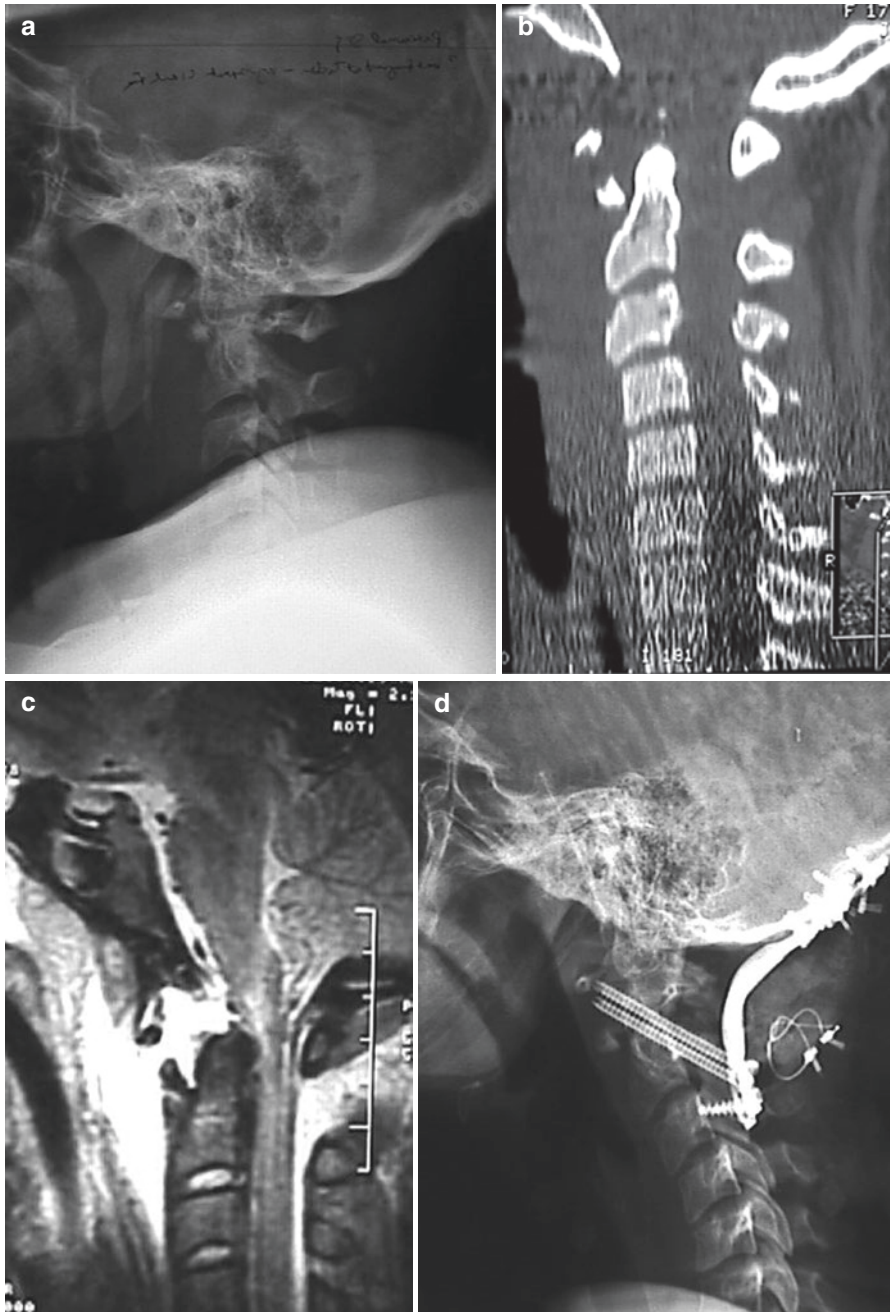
A 17-year-old female presented after high-speed MVC complaining of severe headache and right shoulder weakness. Preoperative X-ray, CT, and MRI demonstrate AOD, C1–2 dislocation, and fracture of anterior ring of C1 with severe ligamentous injuries (a–c). She underwent ORIF from occiput to C3 and made a full recovery (d)
